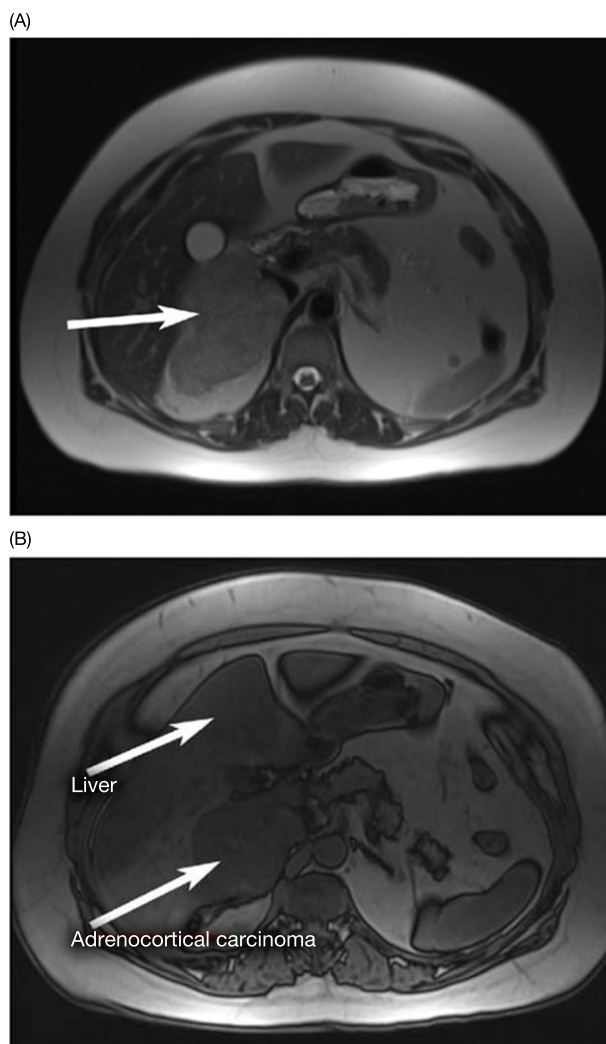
Magnetic resonance imaging (MRI) features of an adrenocortical carcinoma. (A) Adrenocortical carcinoma enhancing on T2-weighted image shows higher intensity than the liver. (B) T1-weighted imaging of adrenocortical carcinoma showing similar intensity to the liver.
